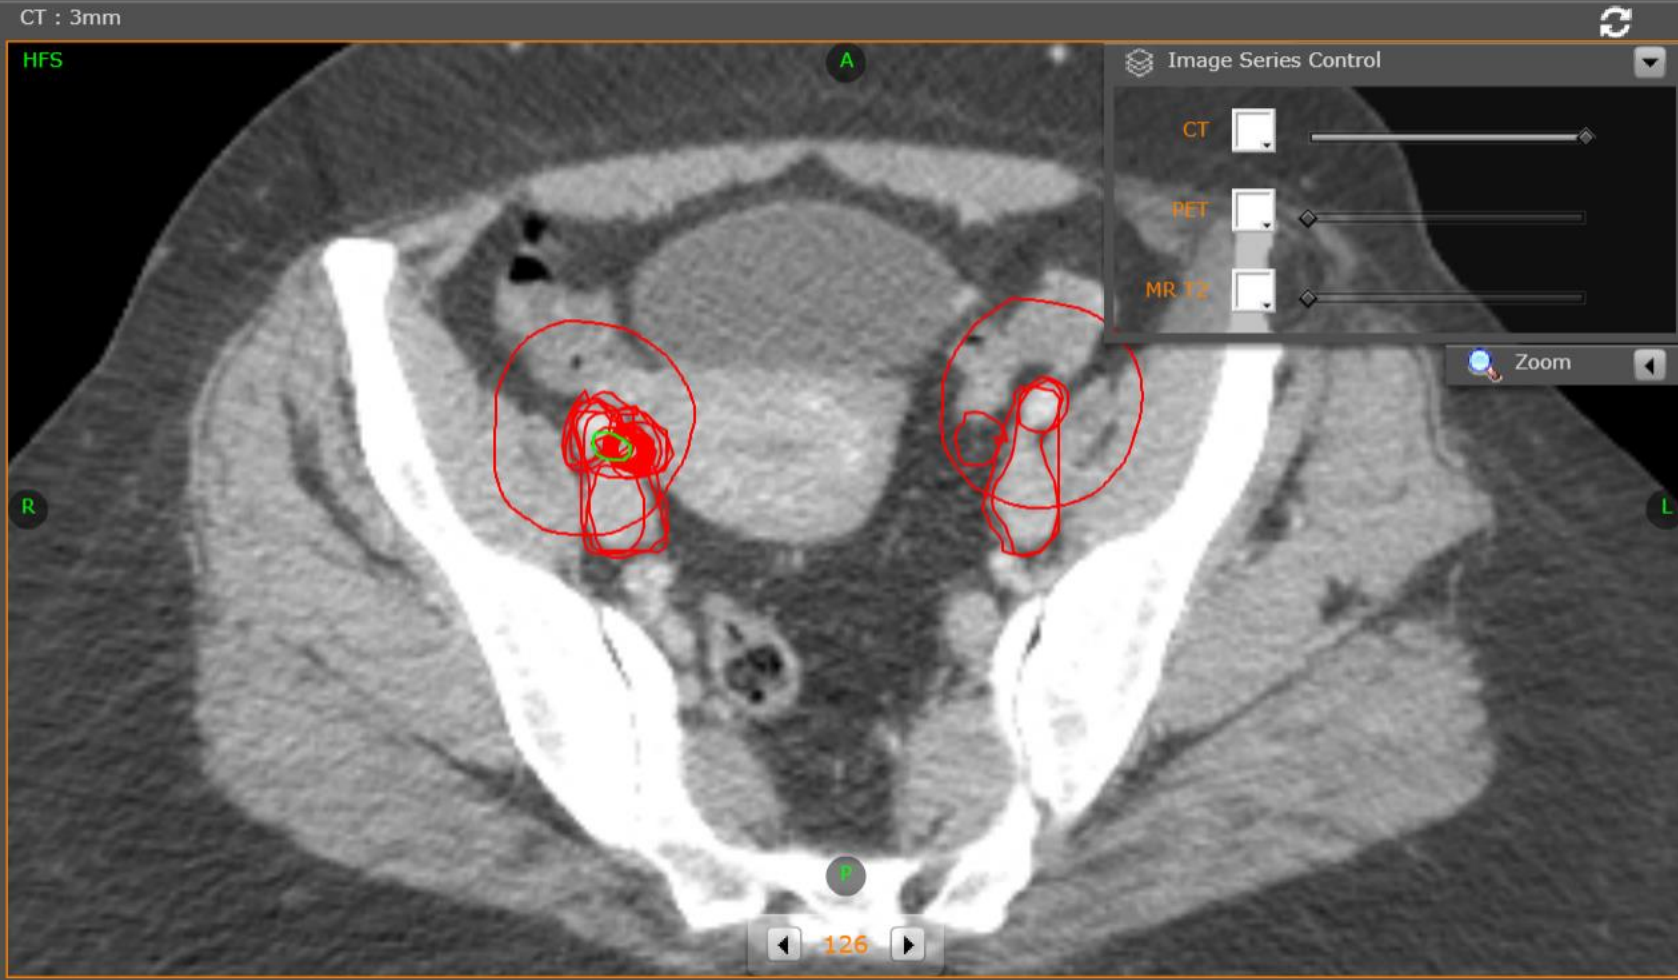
Image Series Control panel with sliders for CT, PET, and MR 12.
